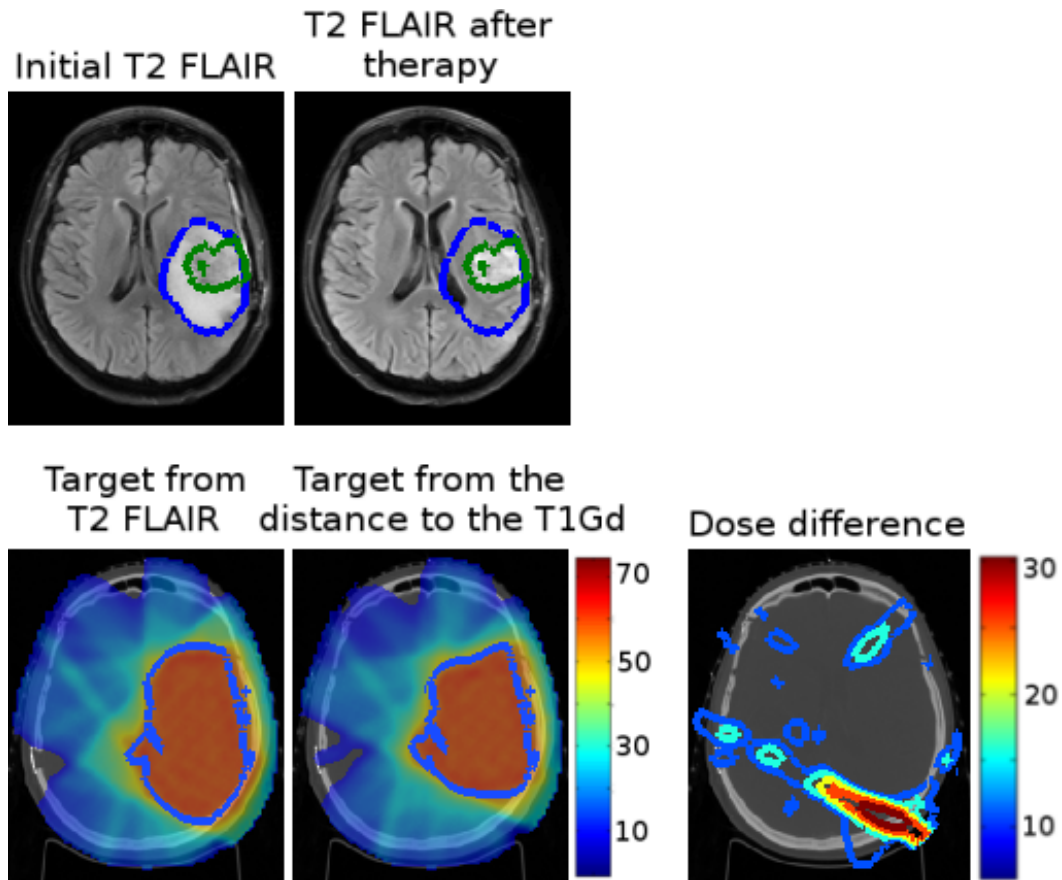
Radiotherapy plans for one patient. The initial (blue) and residual (green) T2-FLAIR abnormalities are outlined on the initial T2-FLAIR (first image) and the T2-FLAIR after radiotherapy (second image). The dose distributions (in Gy) based on CTV1 and CTV2 are overlaid on the CT image (third and fourth images). The target is outlined in blue. The dose difference between the two plans is shown on the right.
